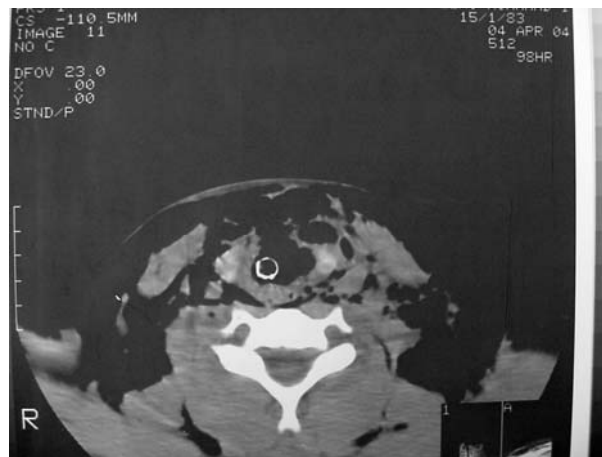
A CT scan showing laryngotracheal disruption in a patient who fell down from a mountain.
